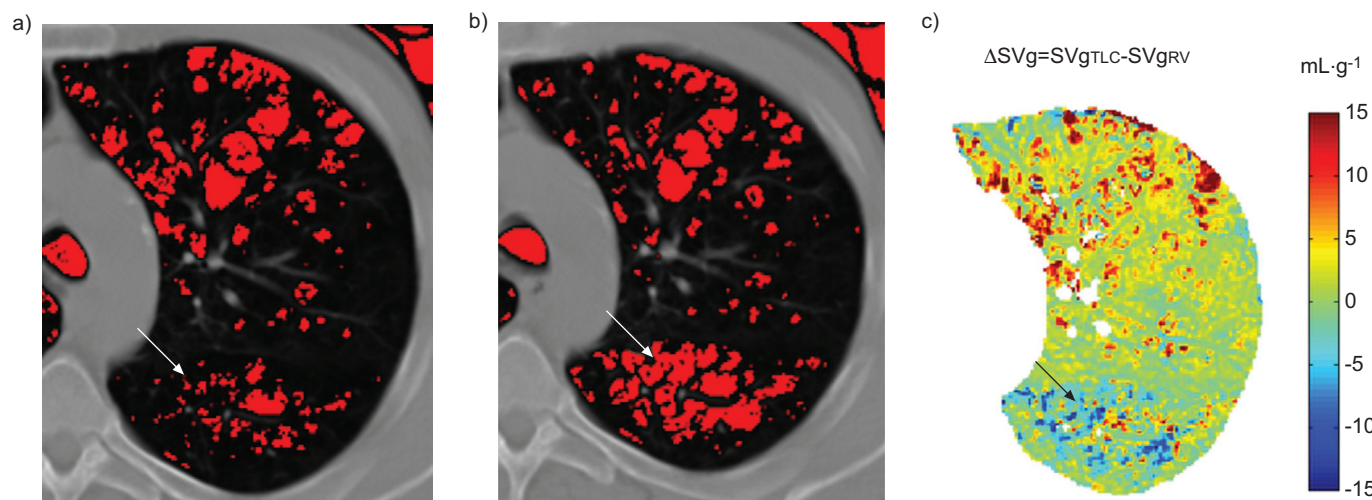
Example of interlobar collateral ventilation assessed by standard computed tomography. We applied a density mask to correspondent images at total lung capacity (TLC) and residual volume (RV) highlighting the pixels below -970 HU: a decrease in density from TLC to RV is clearly visible. The areas where this phenomena happens (e.g. arrows) result in negative change in specific gas volume (Δ SVg) values, shown in blue.
